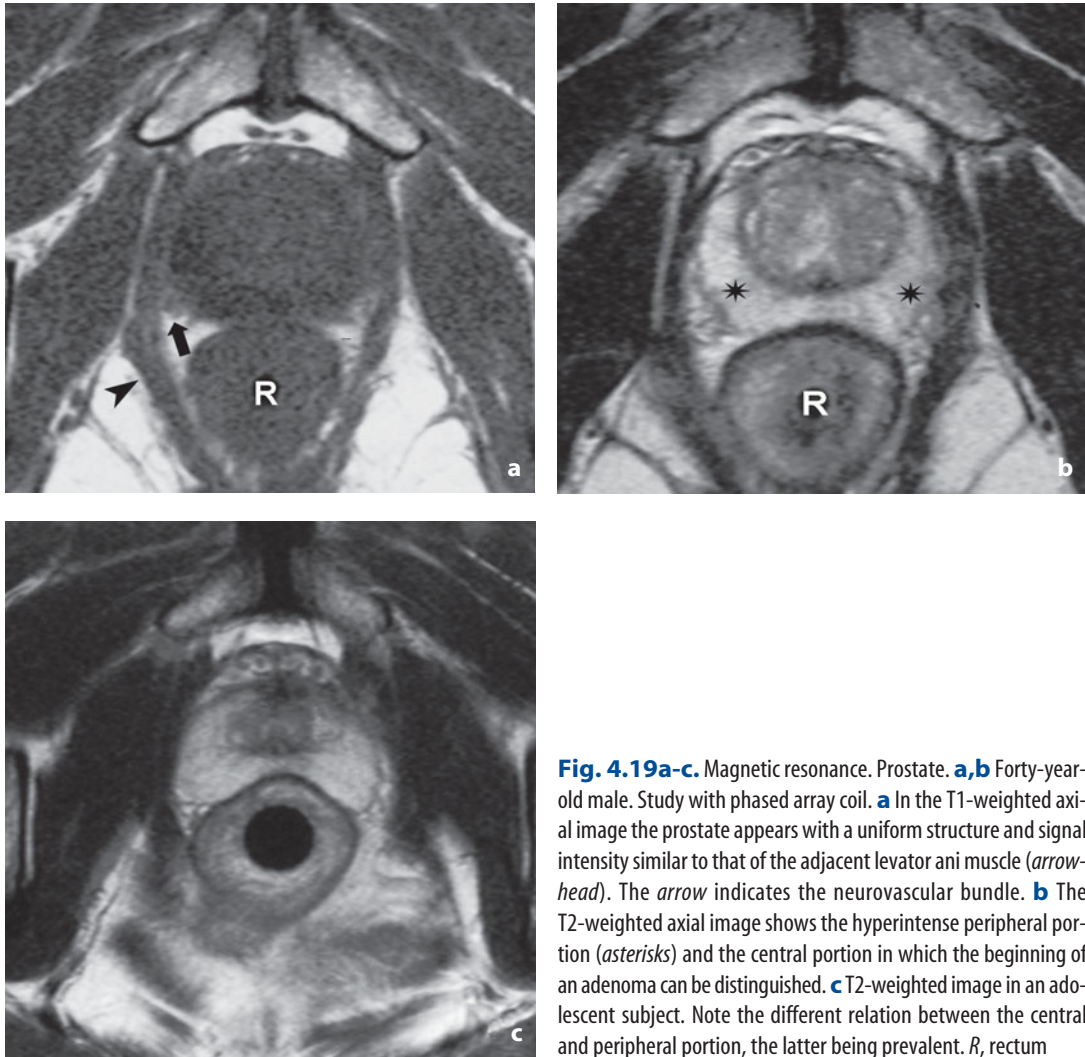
Magnetic resonance. Prostate. a,b Forty-year-old male. Study with phased array coil. a In the T1-weighted axial image the prostate appears with a uniform structure and signal intensity similar to that of the adjacent levator ani muscle (*arrow-head*). The *arrow* indicates the neurovascular bundle. b The T2-weighted axial image shows the hyperintense peripheral portion (*asterisks*) and the central portion in which the beginning of an adenoma can be distinguished. c T2-weighted image in an adolescent subject. Note the different relation between the central and peripheral portion, the latter being prevalent. *R*, rectum
